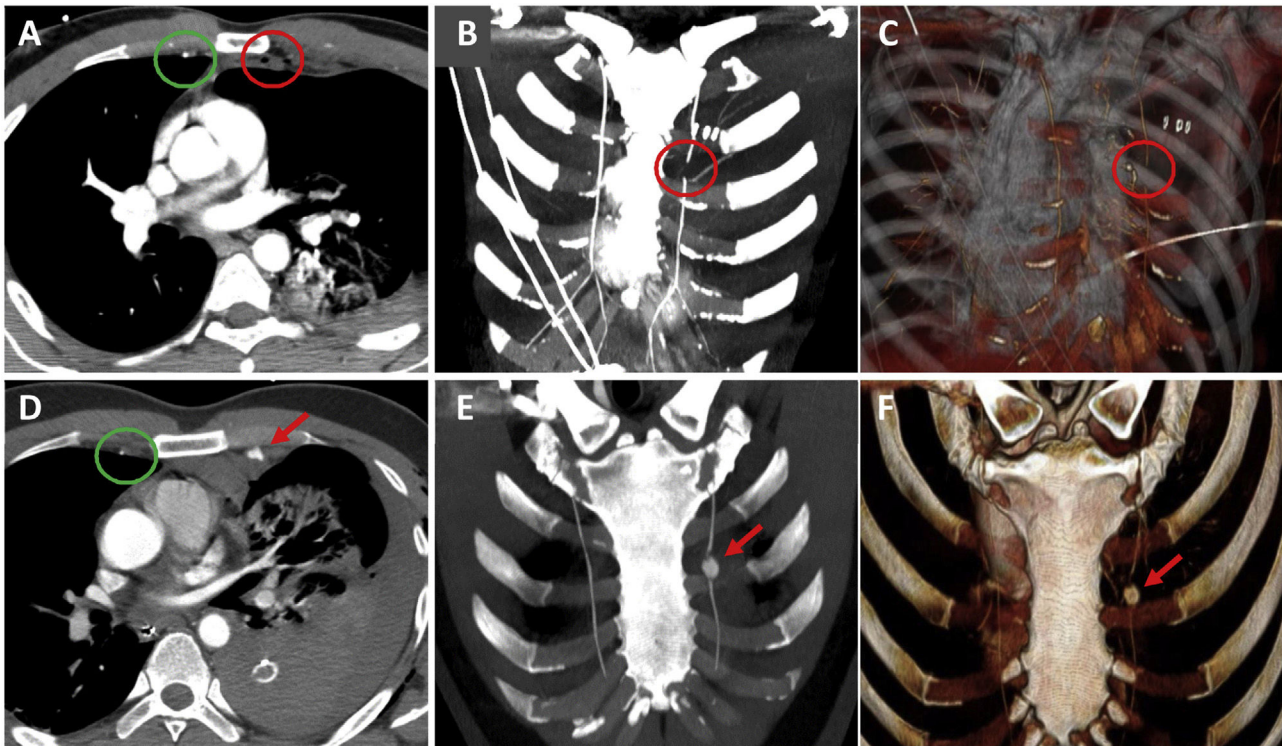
Two male patients following self-harm (self-inflicted stabbing), aged 24 (top row) and 39 (bottom row). Chest CT images reveal findings in the internal thoracic artery (ITA). A-C) Axial image (mediastinal window) (A), coronal maximum intensity projection (MIP) (mediastinal window) reconstruction (B) and 3D reconstruction (C) in which there is an absence of opacification in segments of the left ITA (red circle), compatible with a dissection. D-F) Axial image (mediastinal window) (D), coronal MIP reconstruction (mediastinal window) (E) and 3D reconstruction (F) showing irregular outpouchings in the left ITA, compatible with a pseudoaneurysm (red arrow). The green circle represents the right internal thoracic vessels, which show no alterations. The aim of these two cases is to demonstrate the difficulty in identifying structures that, due to their small size, are only visible in the axial plane in a single slice or are not visible at all (as in the first case), as well as to highlight the usefulness of MIP and 3D reconstructions.
